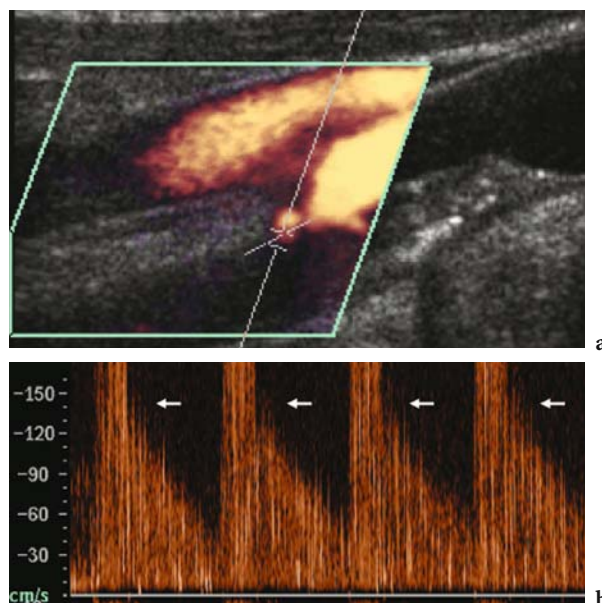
Artefacts from microbubble-based agents. Doppler signal before microbubble injection (a). Excessive amplifications of Doppler signal after microbubble injection (b)
